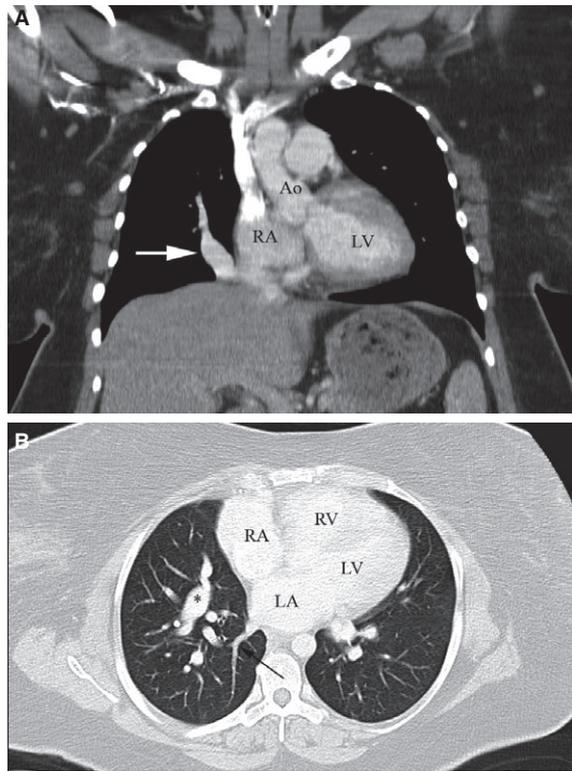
Contrast enhanced CT. A. Coronal view demonstrates scimitar vein (arrow) anomalous drainage into the RA/IVC junction. B. Axial view (lung window) demonstrates a single right pulmonary vein entering normally (arrow) into the left atrium (LA). The scimitar vein (*) is also visualized. Ao = ascending aorta, LA = left atrium, LV = left ventricle, RA = right atrium, RV = right ventricle.
